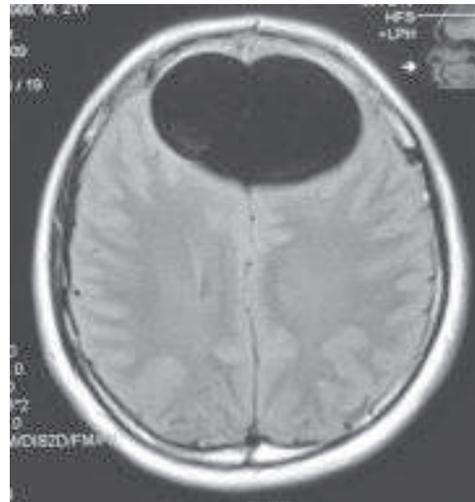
T1WI of MRI showing cystic space occupying the both frontal regions, suggestive of an arachnoid cyst.
